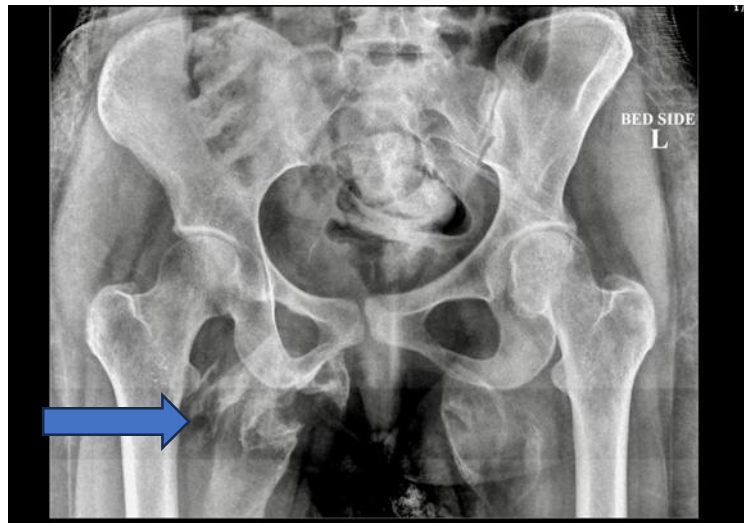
Bedside X-ray of both hips AP view of Case 1
